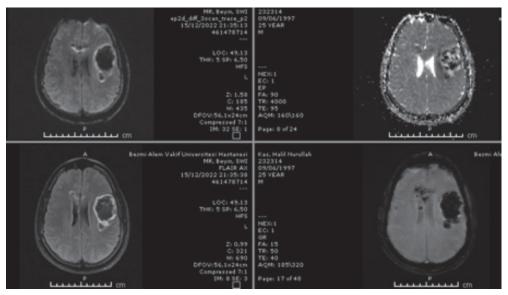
Diffusion MR image
